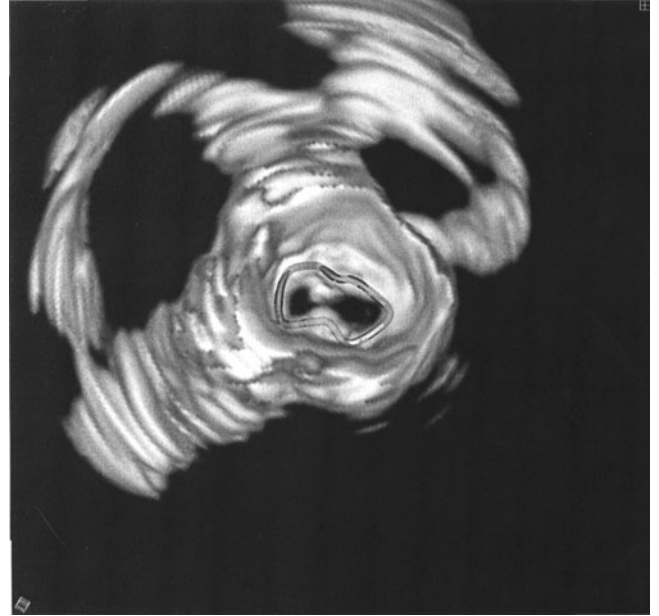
Postoperative three-dimensional echocardiography of a mitral repair performed using the Geoform mitral annuloplasty ring. Note the apposition of the central areas of the anterior and posterior mitral valve leaflets which help to establish a zone of coaptation and abolish mitral regurgitation.
